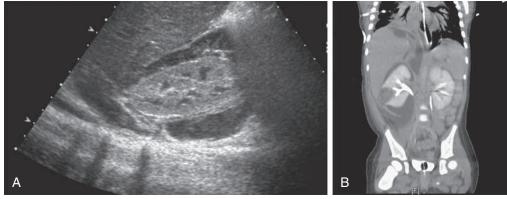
A, Renal sonogram, 19-mo-old infant with perirenal abscess secondary to methicillin-resistant *Staphylococcus aureus*. B, CT scan demonstrates extensive perinephric and focal intrarenal abscess. Patient underwent incision and drainage.
